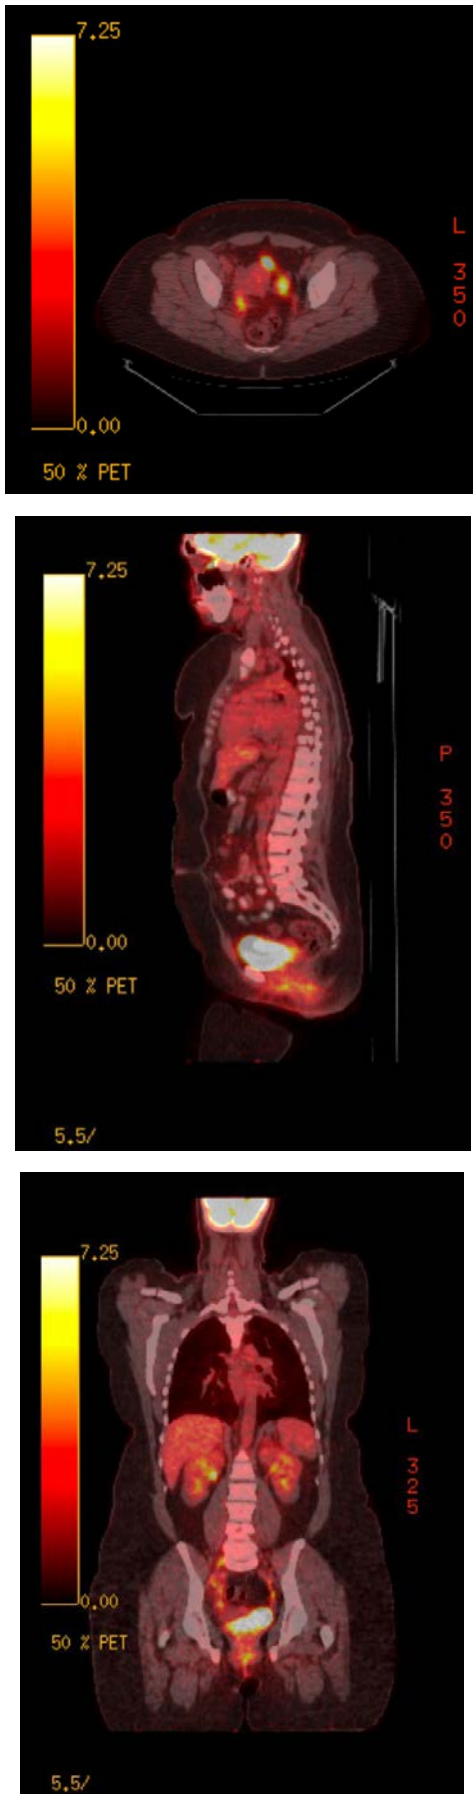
Multiple FDG avid enlarged lymph nodes are seen in the right iliac and lower retroperitoneal lymph nodes
